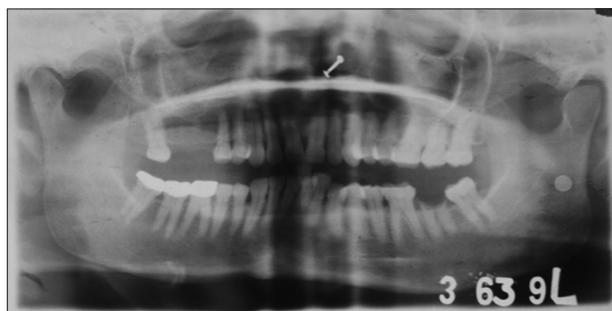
Orthopantomogram showing missing 16 and 17 and root stump with respect to 37. Radiographic artifact evident in the ramus of the mandible
